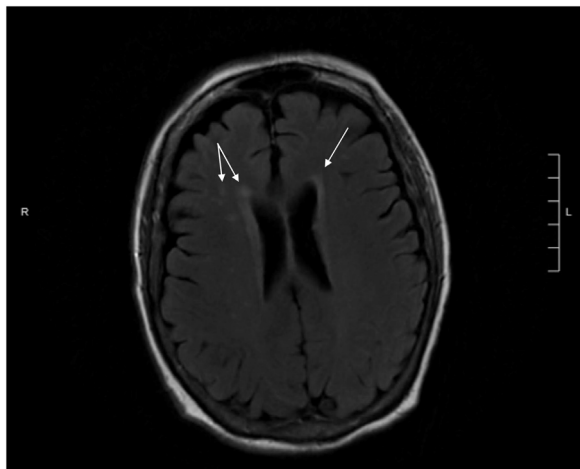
Brain MRI with contrast showing mild punctate high-flair signals in the periventricular deep white matter consistent HHV-6 encephalitis.
